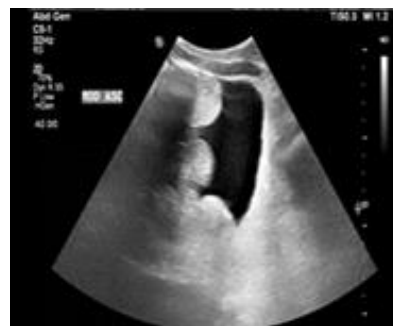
Ultrasound abdomen demonstrates moderate volume ascites with internal echogenic debris, suggestive of complex (exudative) ascites.
